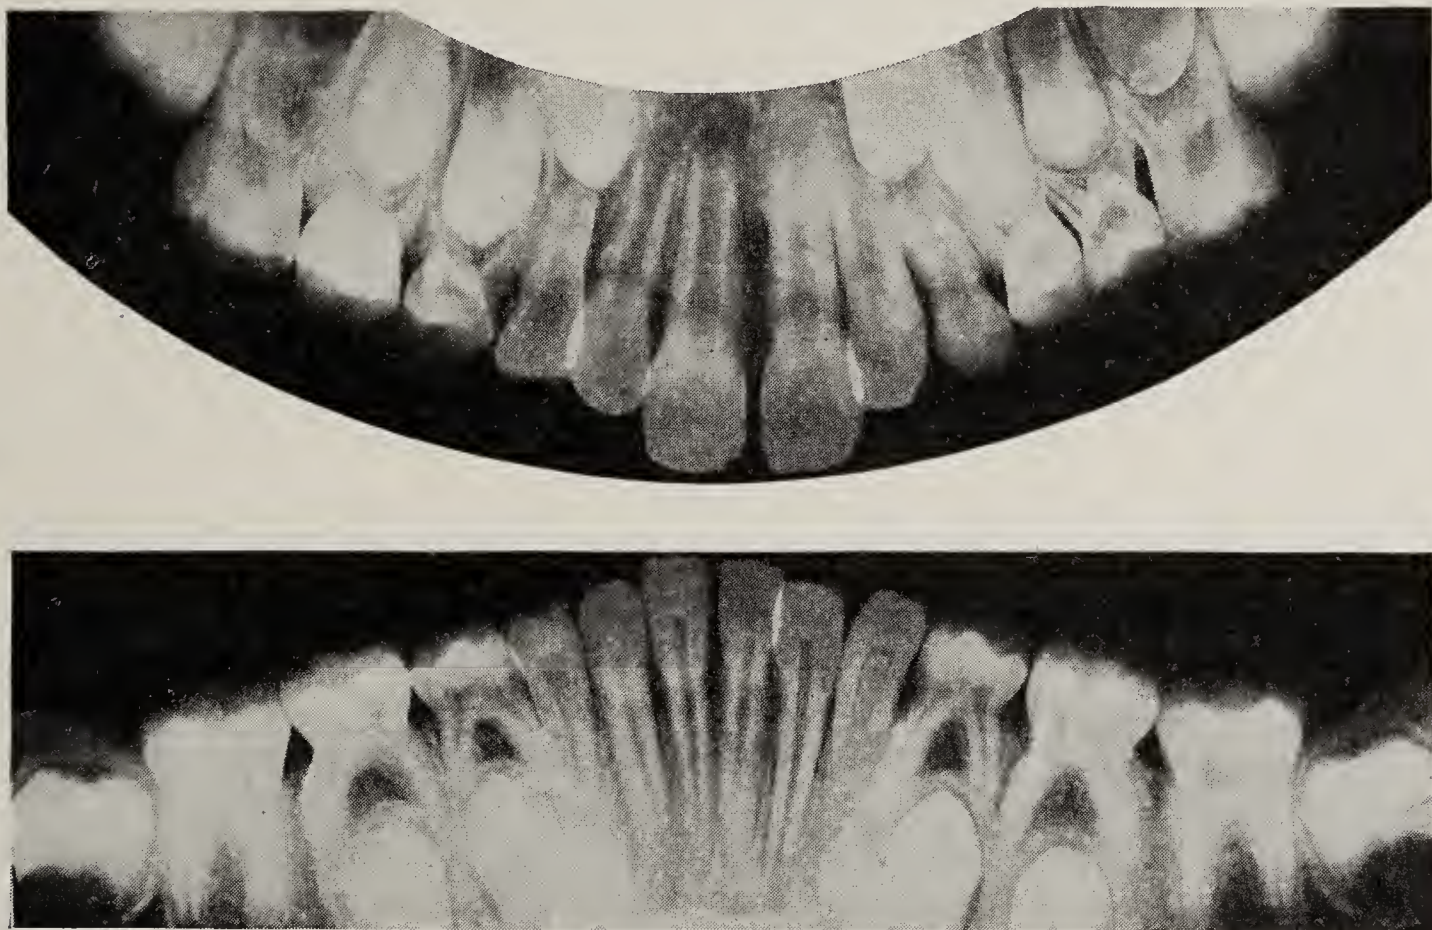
Reproduction of radiographs of teeth of boy nine years of age who participated in the self-selection feeding experiment by Dr. Clara Davis from the time he was six months old and has continued on the same plan since the experiment closed. His teeth are entirely caries free.
